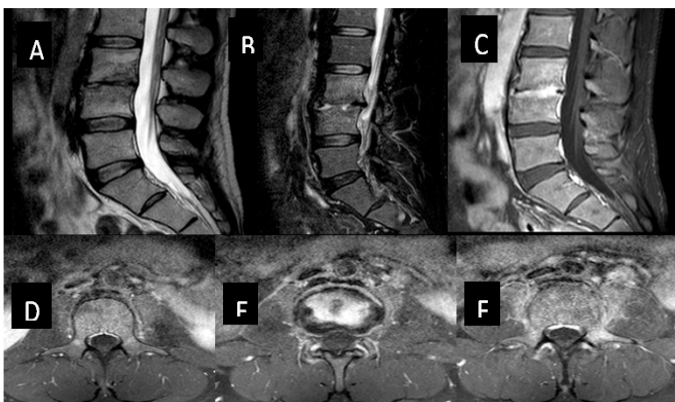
Spinal MRI on the 30th day showed a further reduction in bone marrow oedema (B). Adjacent psoas inflammatory changes are significantly reduced (F).
